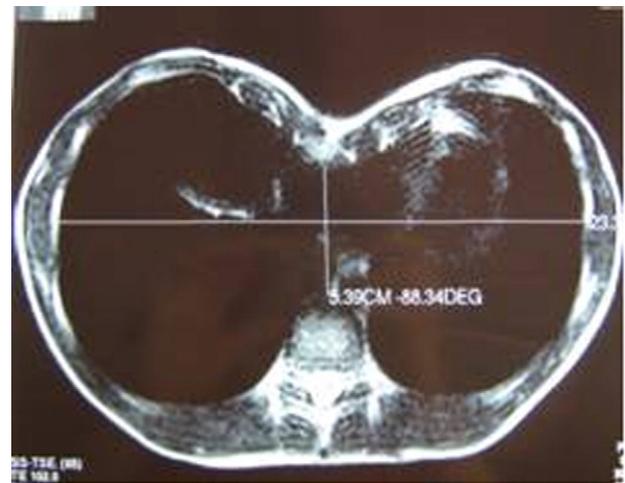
HI calculated from Chest MRI.
